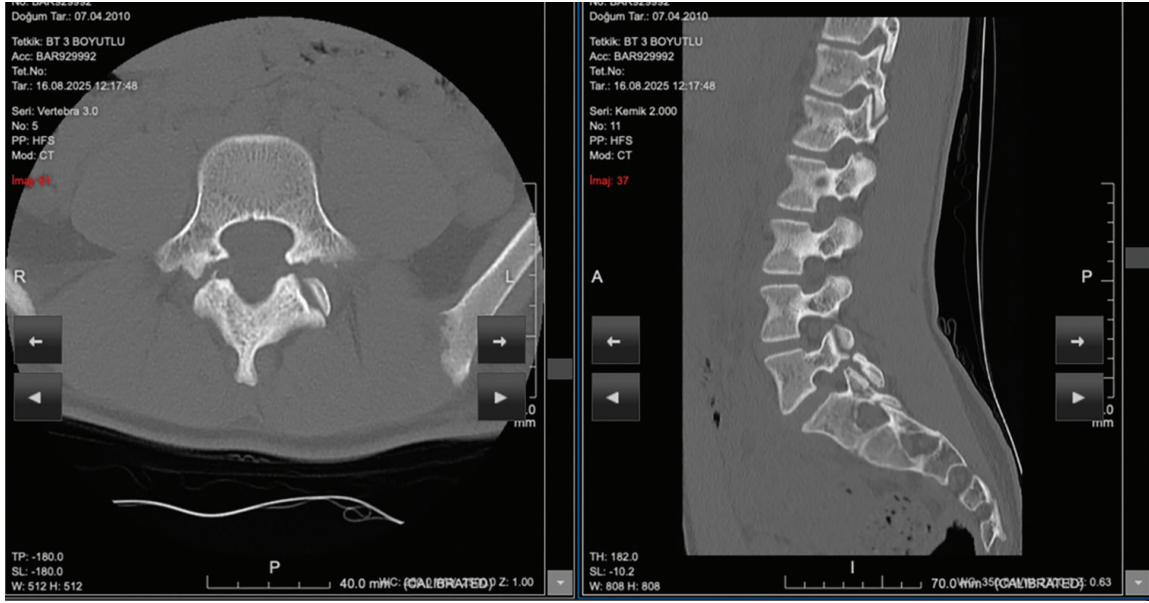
Chronic, non-union of pars defect in 14 years old female gymnast. CT: Computed tomography
